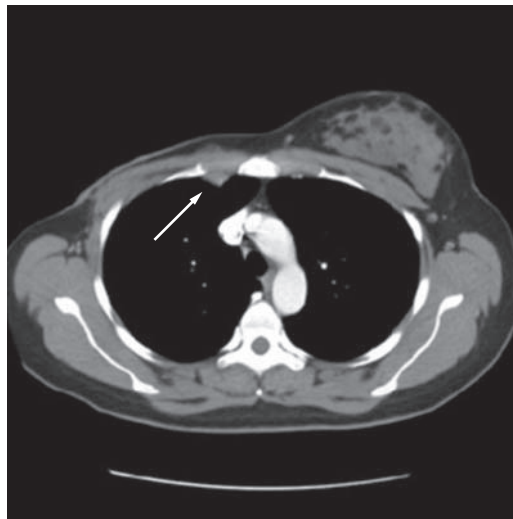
Postpartum contrast-enhanced helical chest CT scan showing an enlarged internal mammary lymph node (white arrow).
